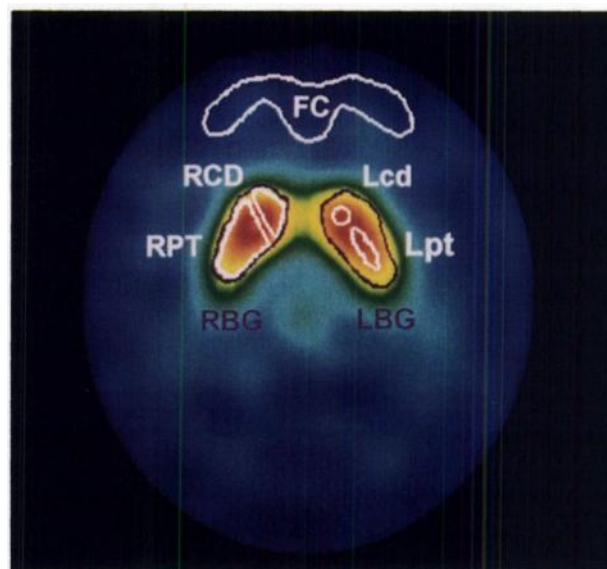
Transaxial IBF SPECT image with typical ROI sets. FC = frontal cortex. LV (right): RBG = right basal ganglia, RCD = right caudate and RPT = right putamen; and SV: LBG = left basal ganglia, Lcd = left caudate and Lpt = left putamen.
